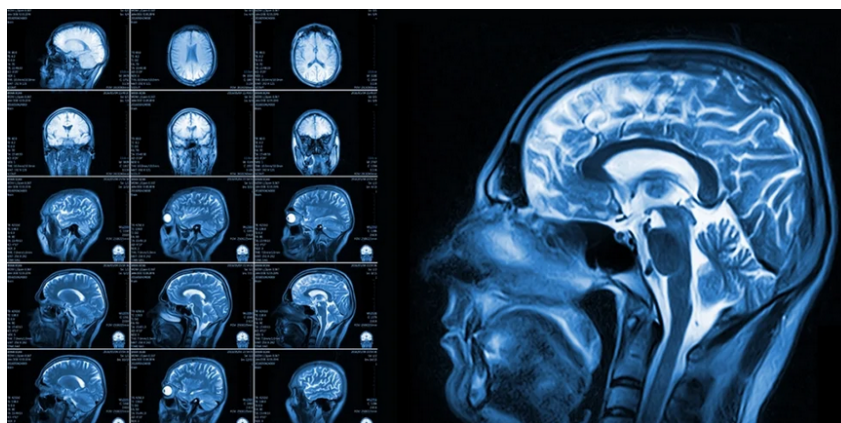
Example of brain MRI image. [3]
